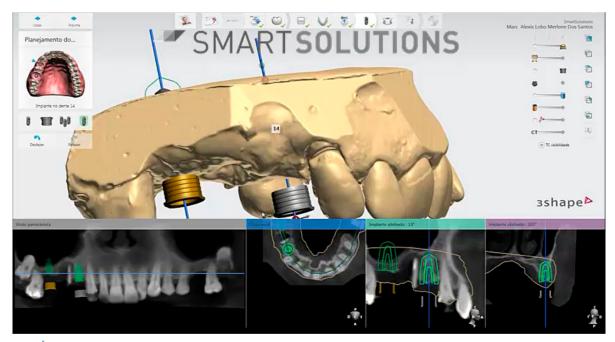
Scanning and computed tomography relationship.
